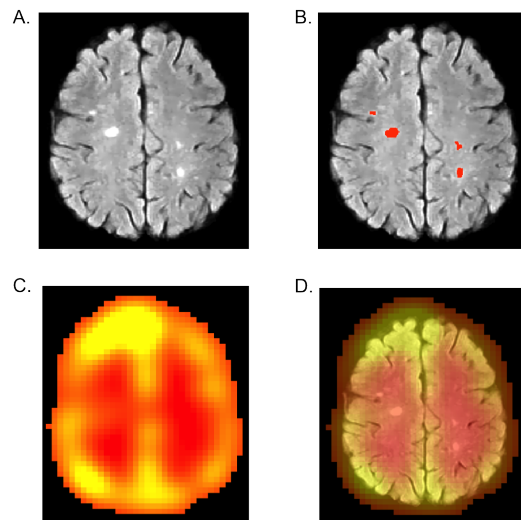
The figure shows the input image with MS lesions (0.5 - 7cm) (A.), the manually traced mask in red overlaid on the input image (B.), the resulting saliency map (C.), and the saliency map overlaid on the MRI image with MS lesions (D.). The yellow areas are the highly salient areas, whereas the red areas are less salient ones.
